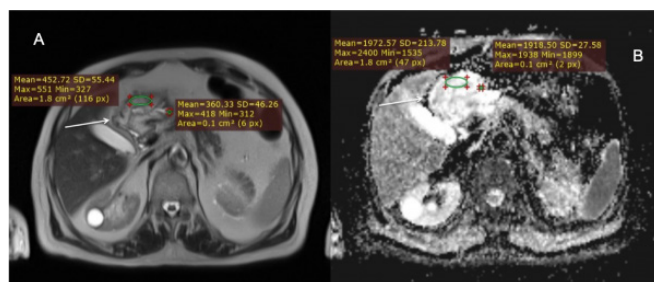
Description of the Figure: A 55 year-old patient with chronic gastritis. (a) Axial T2-weighted MRI image shows slightly hyper-intense symmetric wall thickening in the antrum (arrow). (b) Corresponding apparent diffusion coefficient (ADC) map of the patient. ROIs are copied and pasted from T2-weighted image. The ADC value of the thickened antrum wall (1.972 x10⁻³ mm²/s) is significantly higher than ADC values of the normal gastric wall (1.115 x10⁻³ mm²/s).
